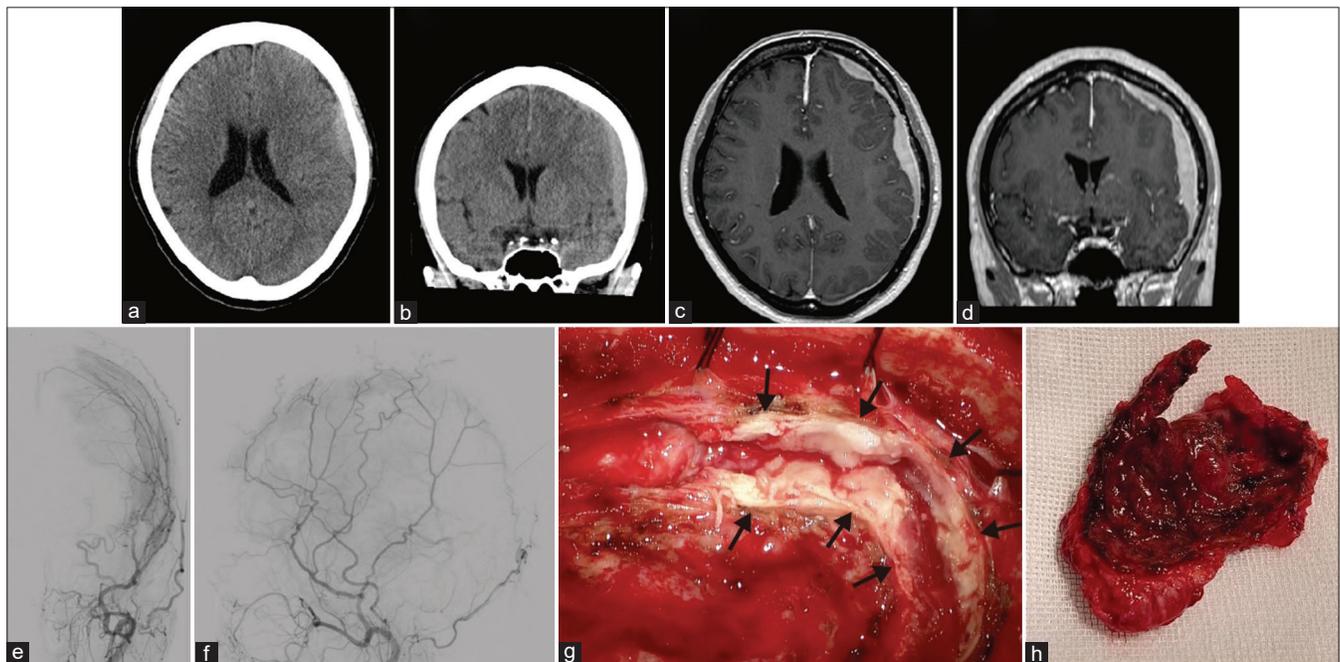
Axial (a) and coronal (b) computed tomography (CT) without contrast demonstrates a high-density subdural lesion. Axial (c) and coronal (d) magnetic resonance imaging with gadolinium contrast show residual contrast-enhancing extra-axial masses in the left frontal, temporal, and parietal lesions. Anteroposterior (e) and lateral (f) view of the left external carotid artery angiogram indicate arterial phase blush within the left convexity lesion. (g and h) Intraoperative findings showed a thickened dura mater (arrows) and a large tumor.
